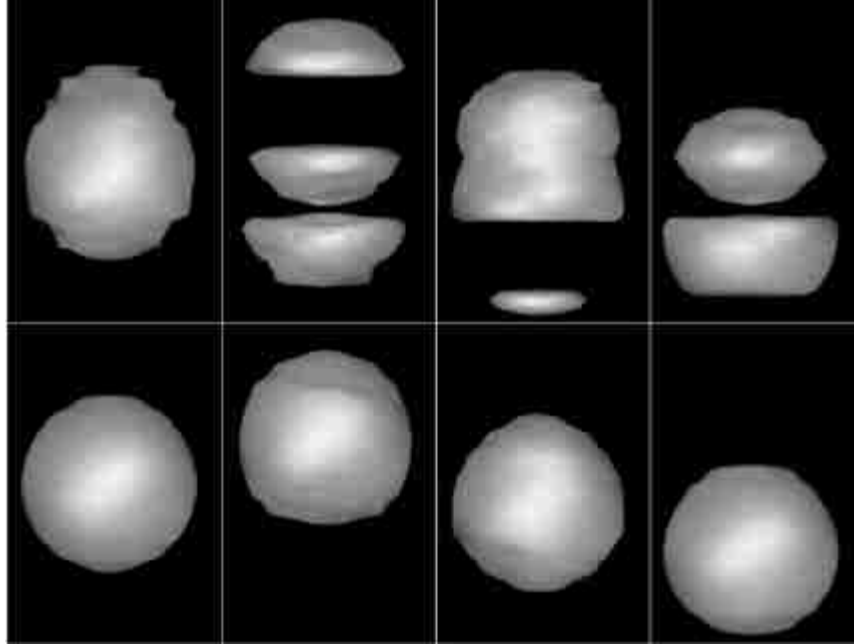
Example of motion artifacts from scanning a moving sphere. Top row: Artifacts of the moving sphere when scanned with a helical free breathing-CT. Bottom row: true geometry of the sphere. (Rietzel *et al.*, 2005)
